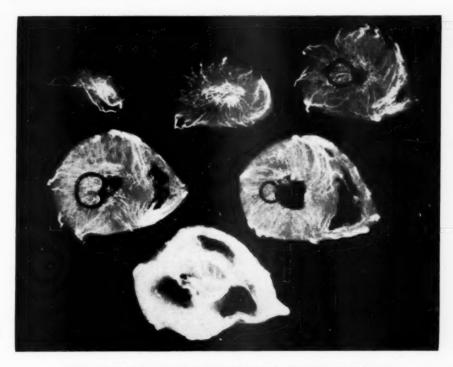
Roentgenogram of the injected heart in Case 144, outlining the position of a subendocardial lateral infarct.
